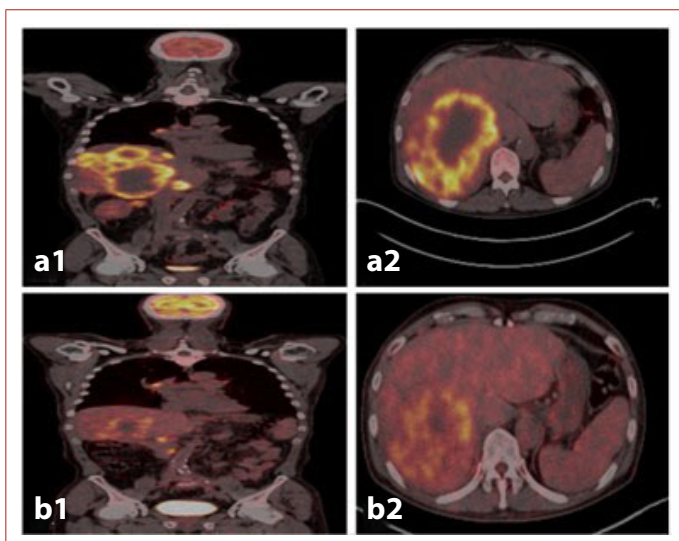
(a1, a2) Pre-treatment PET-CT image of the patient. (b1, b2) PET-CT image obtained 2,5 months after treatment.
